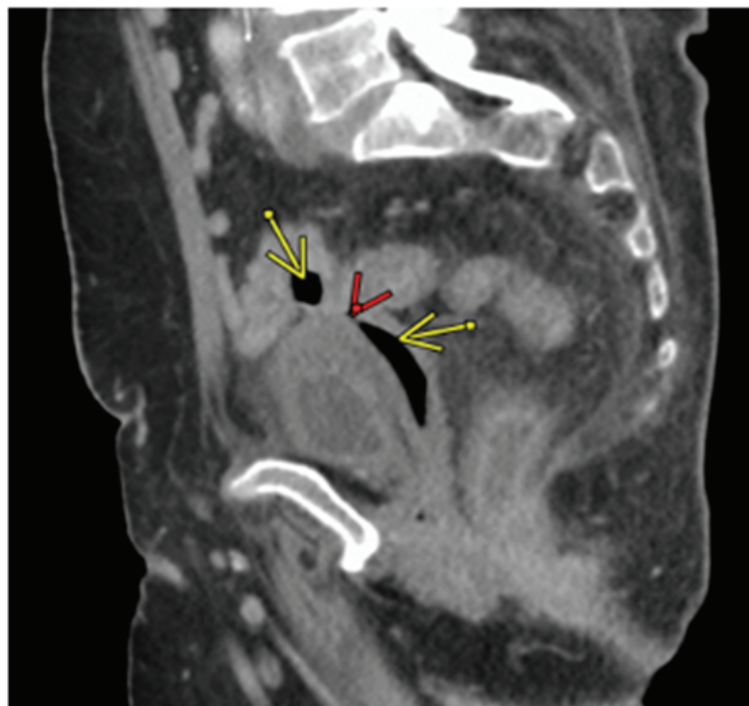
Sagittal view of the patient's colovaginal fistula on CT imaging
